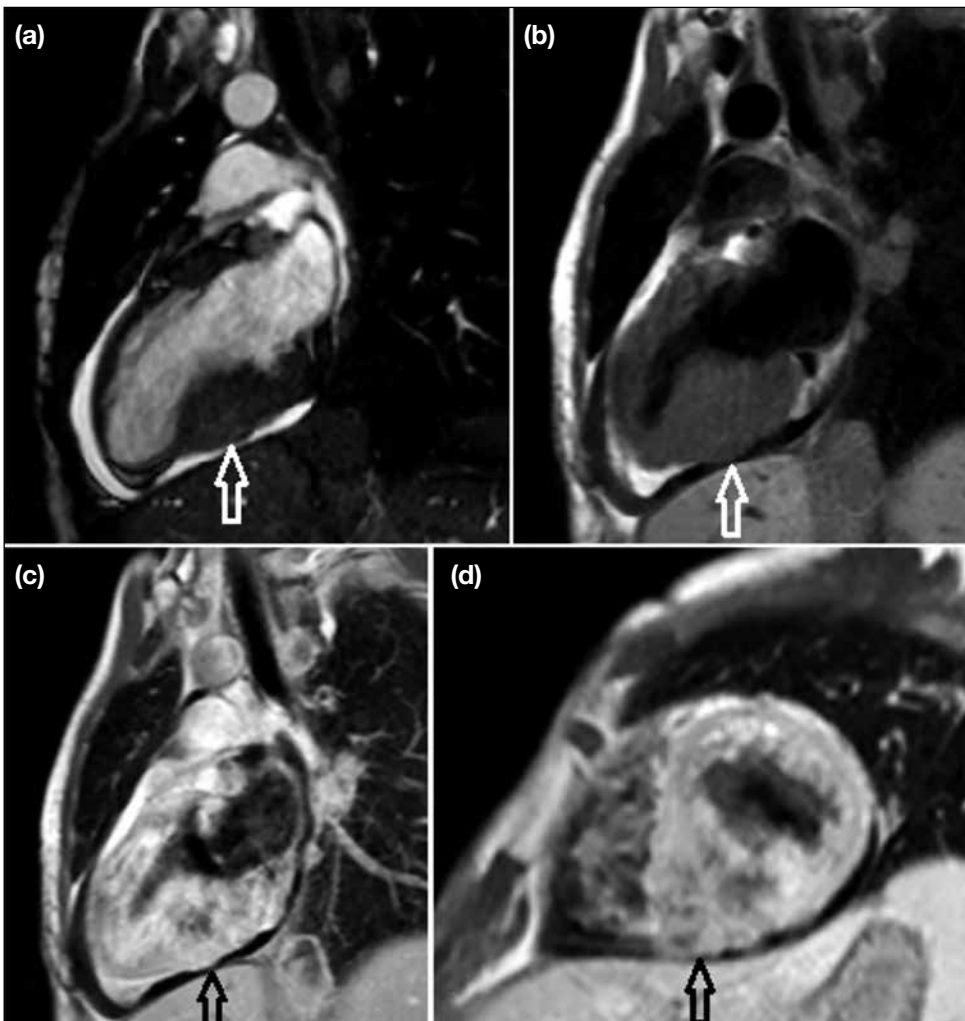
Cardiac magnetic resonance imaging at different sequences of a 24-year-old male patient with a diagnosis of nasopharyngeal carcinoma. Two-chamber planes showed an irregular expansion of the inferior wall of the left ventricle (arrows in a-c). (d) The short axis image demonstrates asymmetrical involvement of the left ventricle by the metastatic mass (arrow). The patient also had bilateral adrenal and lung metastases (not shown). (a) Two-chamber cine steady-state free precession gradient echo sequence. (b) Two-chamber T1-weighted double inversion black-blood turbo spin echo sequence. (c) Two-chamber phase-sensitive inversion recovery sequence with late gadolinium enhancement. (d) Short-axis phase-sensitive inversion recovery sequence with late gadolinium enhancement.
